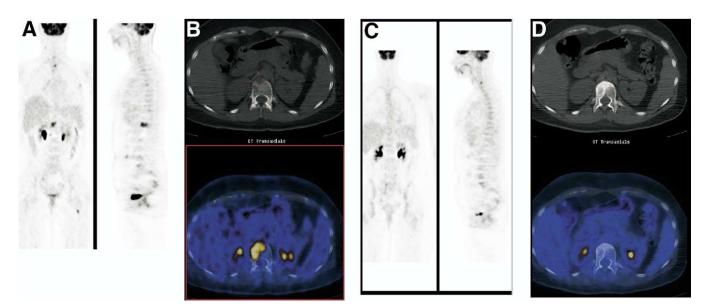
Monitoring response to treatment in a 35-year-old woman with breast cancer. (A) Initial FDG-PET study, coronal and sagittal slices, performed for further evaluation of rising tumor serum markers, indicates the presence of abnormal tracer uptake involving the cervical spine, L-1 vertebra and left proximal femur, consistent with bone metastases. (B) Fused PET/CT transaxial image (bottom) localize the area of pathological uptake in the lumbar spine to a lytic lesion as seen on the corresponding CT component of the study (top). (C) Follow-up FDG-PET performed after 4 months of chemotherapy shows marked improvement with normal tracer uptake in the L-1 vertebra and left femur, and marked decrease in the cervical spine. (D) Follow-up fused PET-CT transaxial image at the level of the lumbar spine (bottom) show no abnormal tracer uptake in the vertebral body, whereas marked osteoblastic reaction is demonstrated on the corresponding CT component of the study (top).
